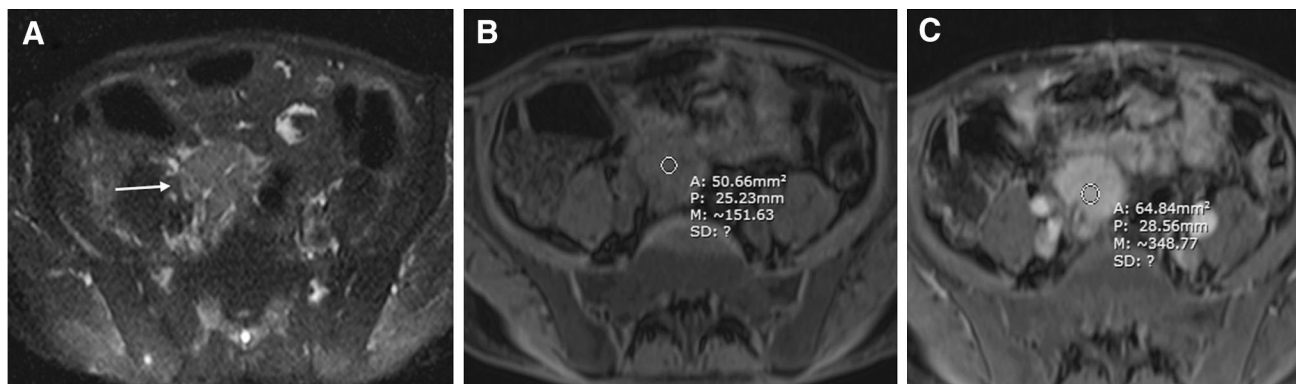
47-year-old man with normal transplanted pancreas. A Transverse T2-weighted image with fat saturation shows a normal transplanted pancreas with normal size and homogeneous signal intensity (arrow). B, C Transverse T1-weighted
